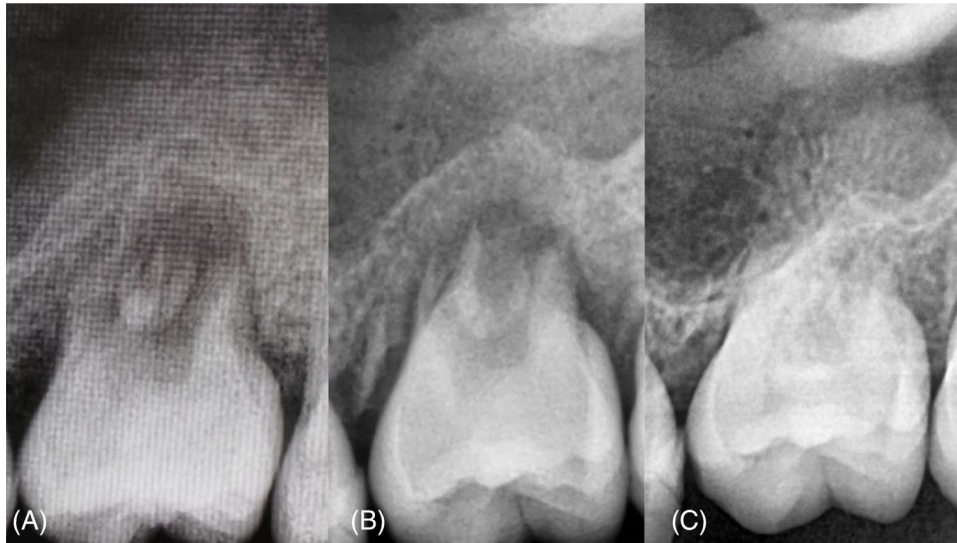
(A) Periapical radiograph immediately after transplantation. (B) 12-month follow-up. (C) 24-month follow-up.
